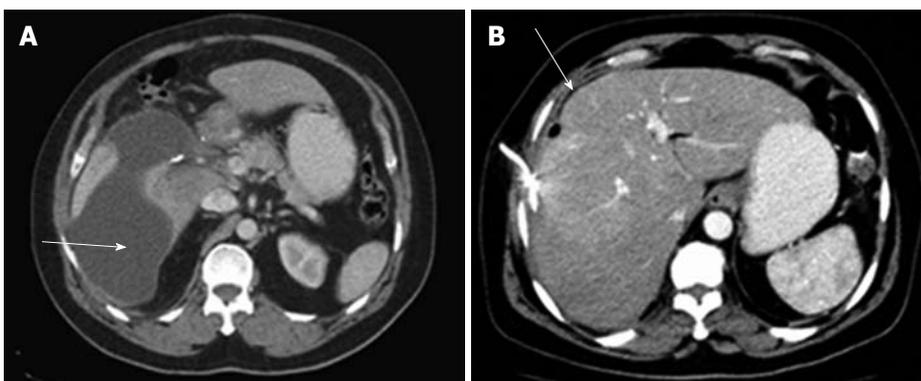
A case of post cholecystectomy biloma. A: Abdominal computed tomography (CT) shows a large subhepatic biloma (arrow); B: CT-guided drainage of the biloma shows marked regression of the volume of the collection (arrow).
